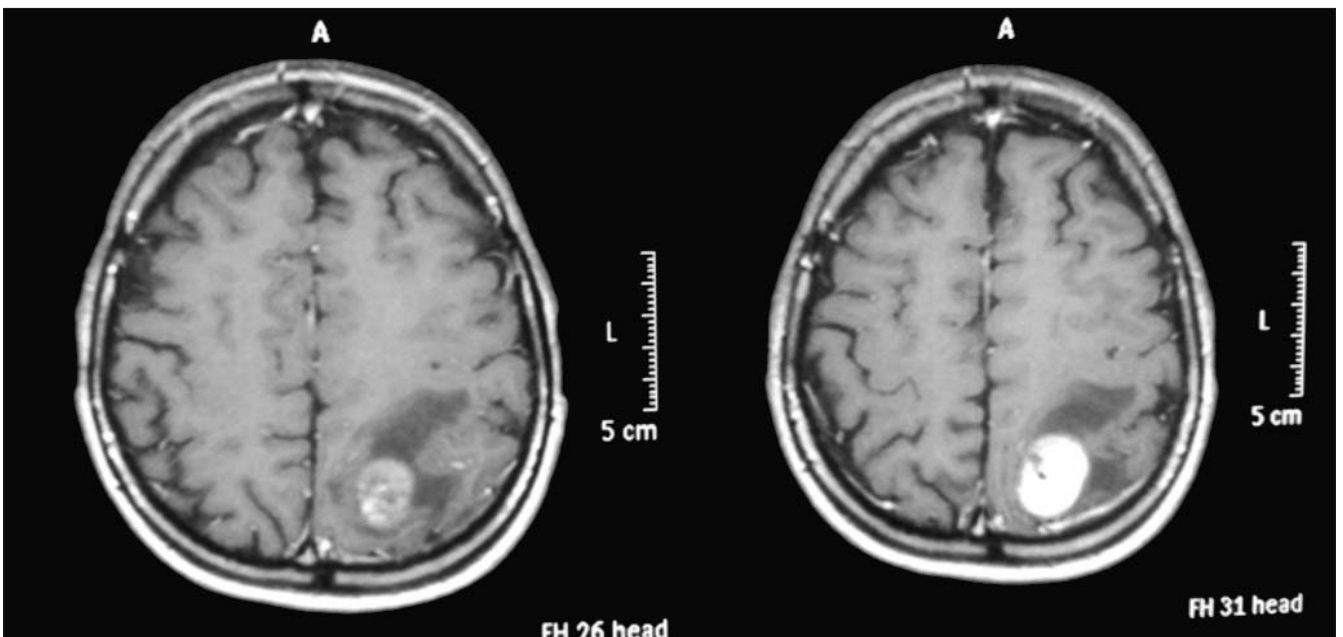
Postoperative brain MRI – secondary brain determination
